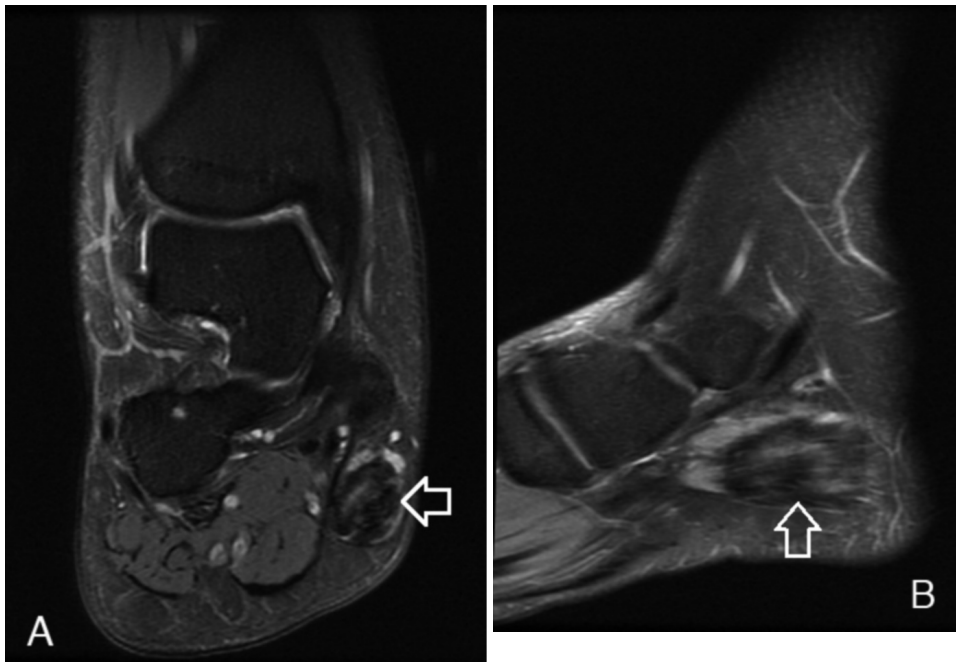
MRI of a 15-year-old with atraumatic right foot and ankle pain presenting for 5-month follow-up examination. A. Coronal fat-saturated proton density demonstrates fatty replacement of the abductor hallucis muscle (arrow). B. Sagittal fat-saturated T2 demonstrates similar findings (arrow).
